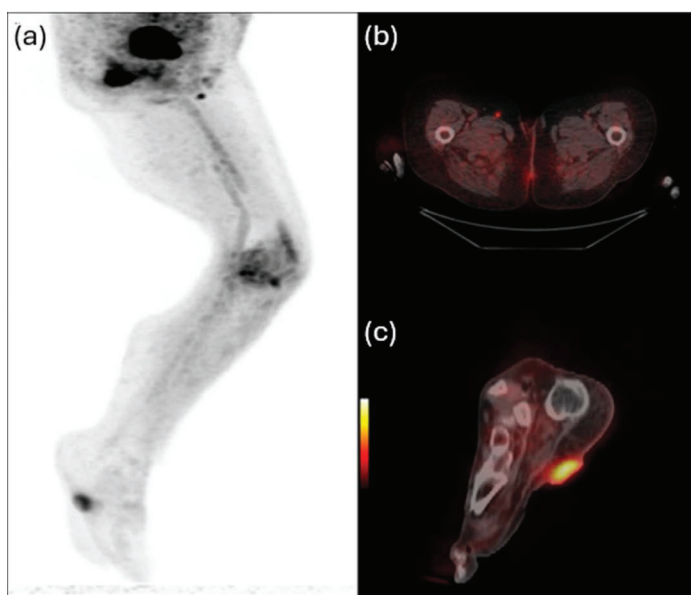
Initial PET / CT scan. (a) Maximum intensity projection image of the lower extremities showing FDG uptake in the right inguinal-femoral region and right plantar foot. (b) Hypermetabolic lymph nodes in the right inguinal-femoral region (SUVmax: 1.4). (c) Pathological metabolic activity in the right plantar foot consistent with primary malignancy (SUVmax: 4.6). FDG - Fluorodeoxyglucose; PET / CT - Positron emission tomography - computed tomography; SUVmax: Maximum standardized uptake value.
